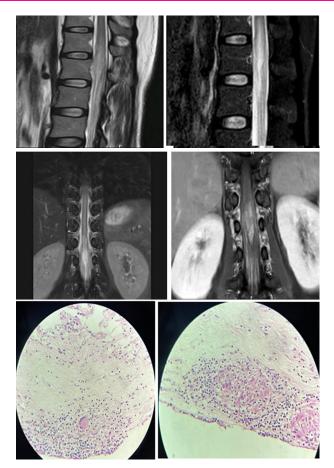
41 years female with progressive paraparesis with bowel and bladder involvement of 5 months duration with fever and constitutional features MRI of spine T2 and T1 contrast revealed an ill-marginated heterogeneously enhancing lesion measuring approximately 9.5x8.0x48 mm (APxTRxCC) in the region of conus medullaris with associated thickening and enhancement of cauda equina nerve roots.
